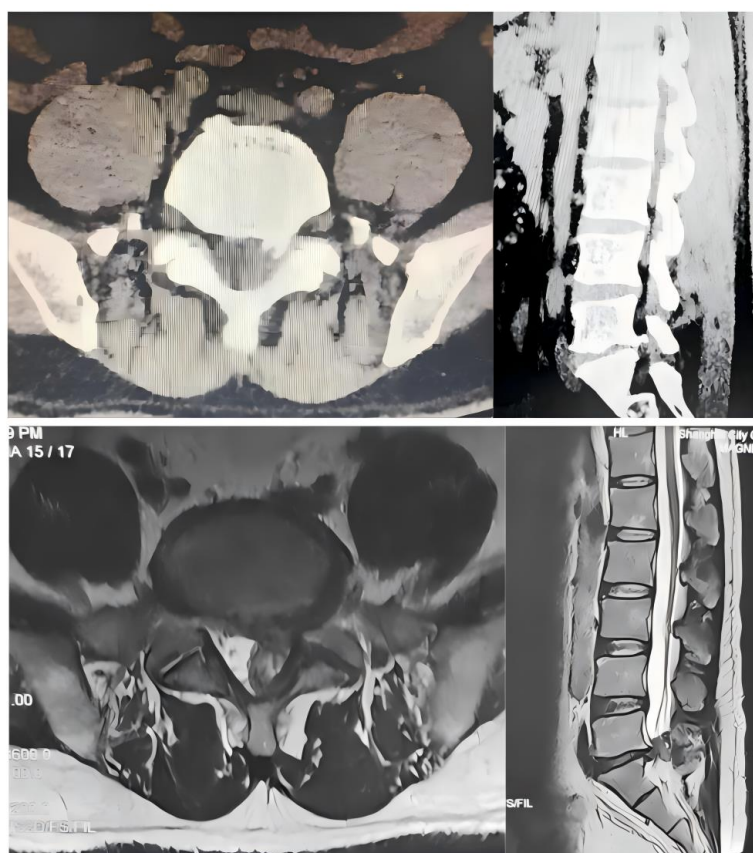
Preoperative MRI and CT view. Patient was suffered from prompt lumbar degenerative disease, L5 / S1 disc herniation, the corresponding level of spinal stenosis.
